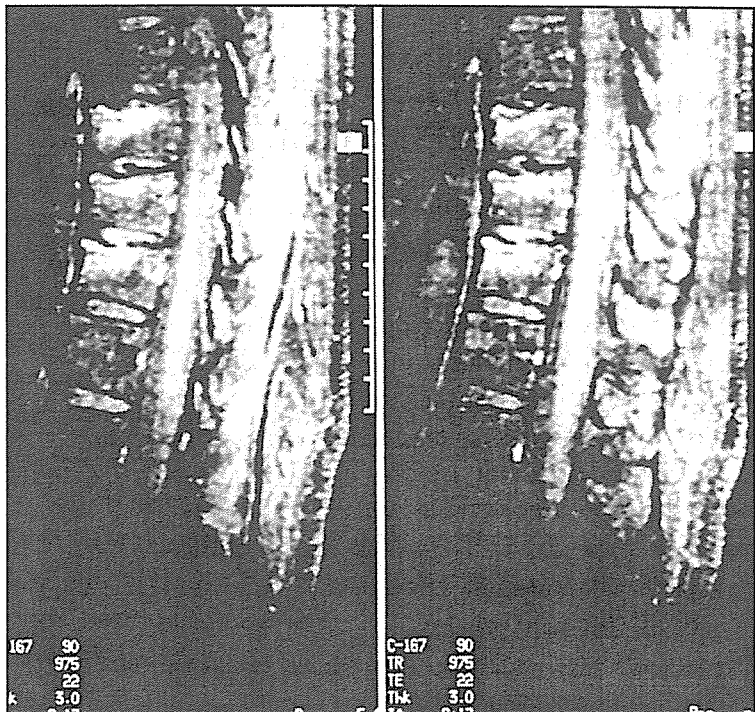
Sagittal plane MRI image shows oedematous tissue swelling like bone bruising and compression fracture at T9, T10 and T11 vertebrae.
